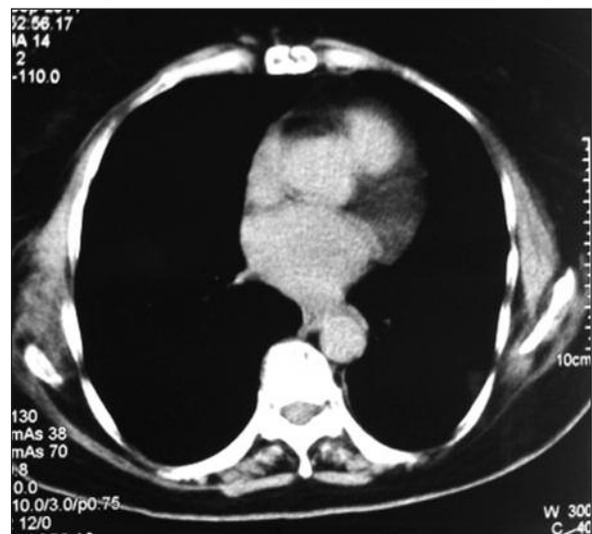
Cross-section computed tomography of left atrium. Left atrial mass cannot be observed.
